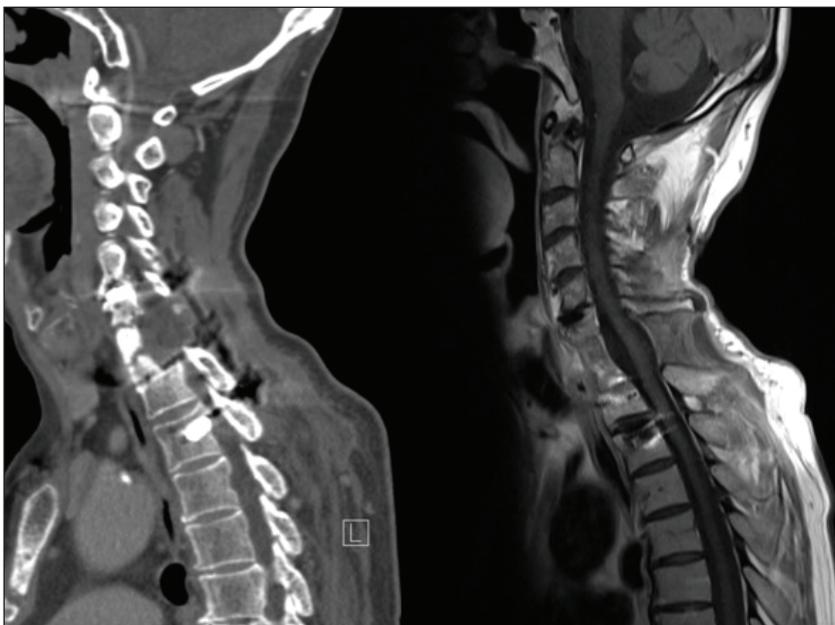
Left image: postoperative 6 month CT scan, midsagittal view in patient 2. Right image: T1-weighted contrast-enhanced MRI, midsagittal view in patient 2.
